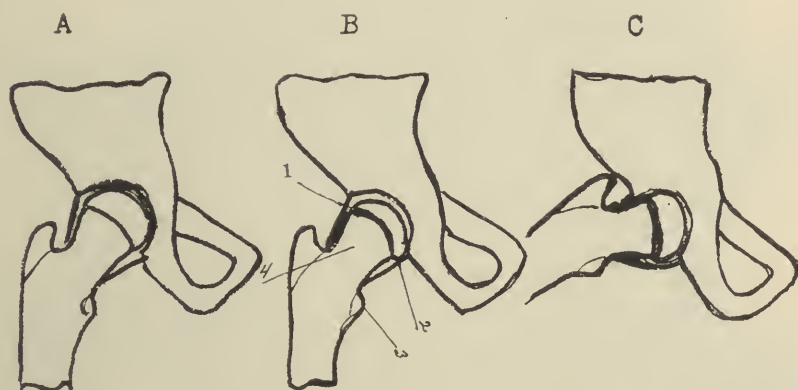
A. The normal joint. B. The changes observed in the roentgen-ray picture in the early stage of epiphyseal displacement. 1. The upper border of the head and neck form an unbroken line in the same plane. 2. The lower border of the epiphysis projects downward in its relation to the neck. 3. The epiphysis appears shallower than the normal. 4. The neck appears, because of the outward rotation, shorter and thicker than the normal. C. Shows that in complete abduction pressure is removed from the epiphyseal junction.
